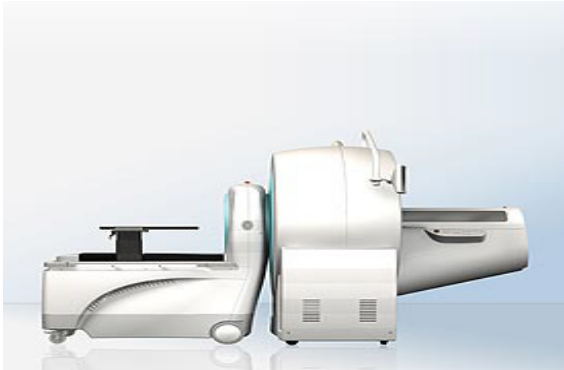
A clinically accepted multi-modal imaging system. The Siemens Inveon Docked PET•SPECT•CT system combines a Docked PET scanner with a SPECT•CT system (Figure courtesy of P.N. Prasad).
